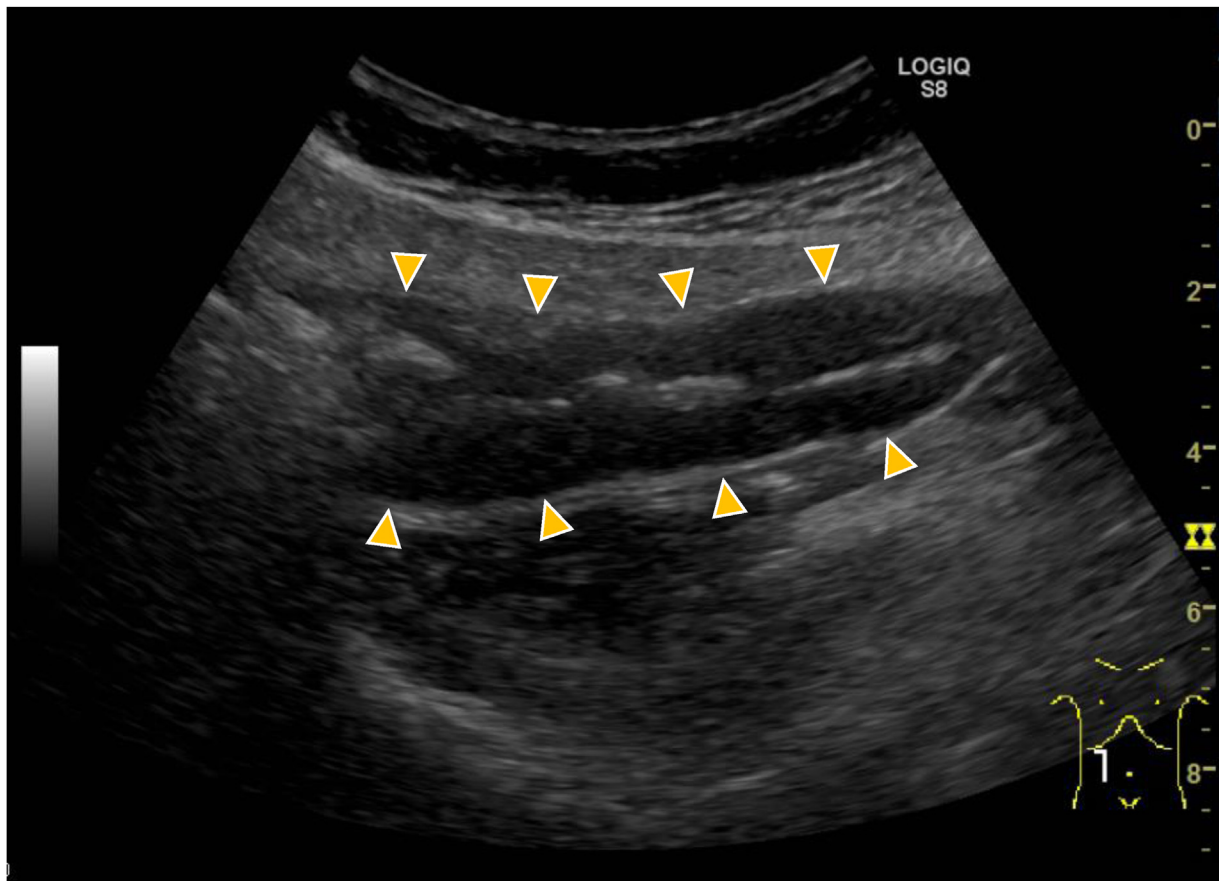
An abdominal ultrasound scan depicting the dilated small intestine with stagnant contents.
